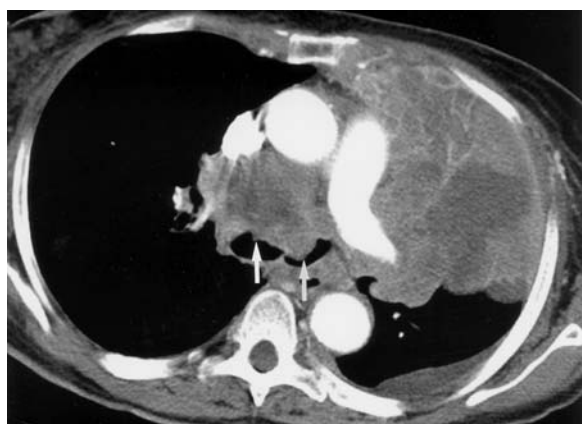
Advanced-stage, inoperable non-small cell lung cancer. Contrast-enhanced axial CT image of patient with extensive non-small cell lung cancer demonstrates extensive mediastinal involvement, including invasion of the airway at level of carina. Note extension of neoplasm into proximal mainstem bronchi (arrows). Also note centrally obstructing tumor, with associated left upper lobe collapse
